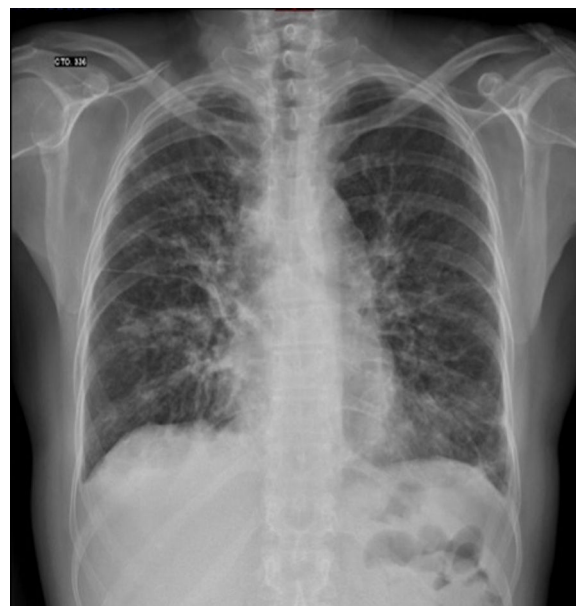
Chest radiograph showing cardiac silhouette of normal size and position, but with abnormal left profile and aorta unrolled. Interstitial lung bilateral thickening, reticulonodular parahilar and basal pattern and bone changes (osteopenia).
